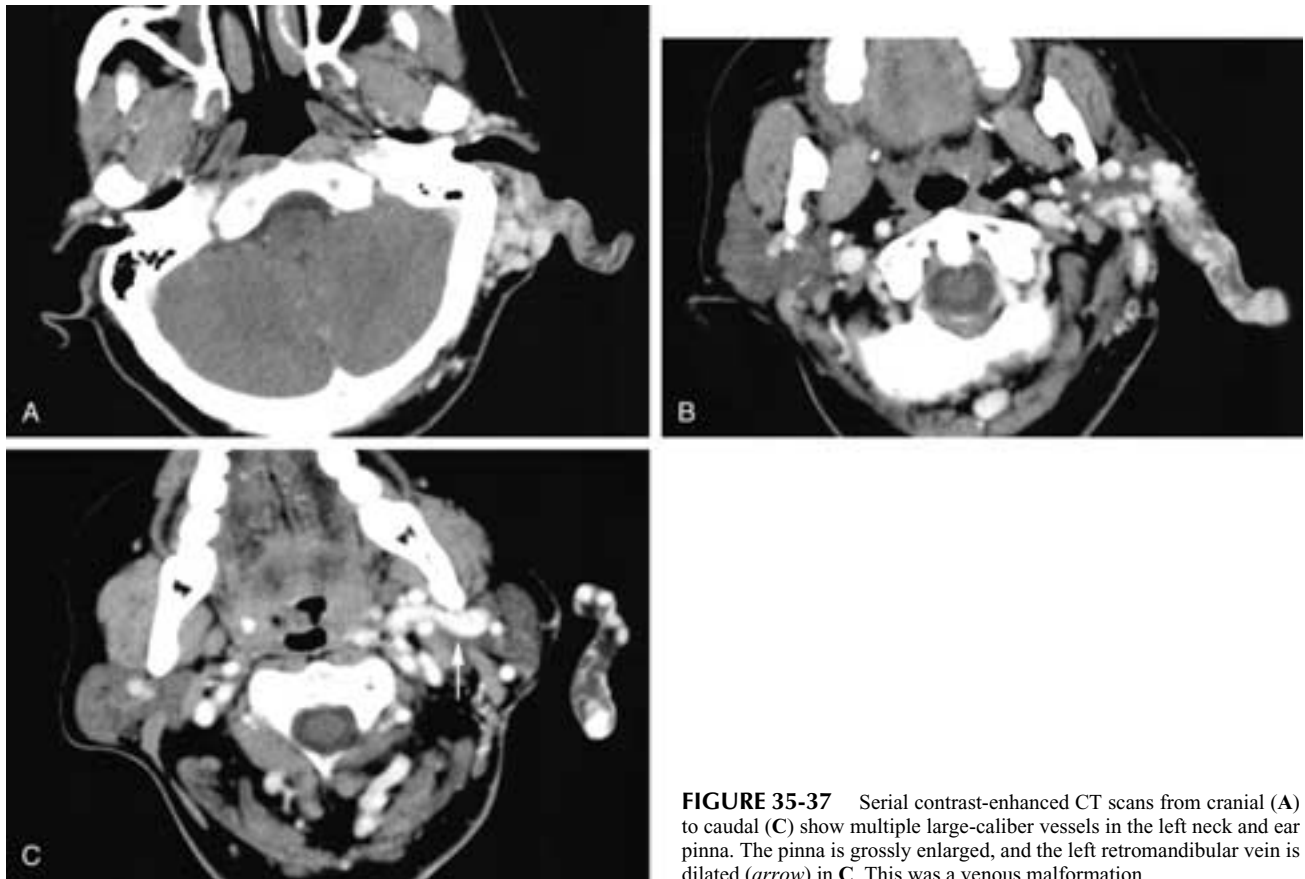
Serial contrast-enhanced CT scans from cranial (A) to caudal (C) show multiple large-caliber vessels in the left neck and ear pinna. The pinna is grossly enlarged, and the left retromandibular vein is dilated (*arrow*) in C. This was a venous malformation.
